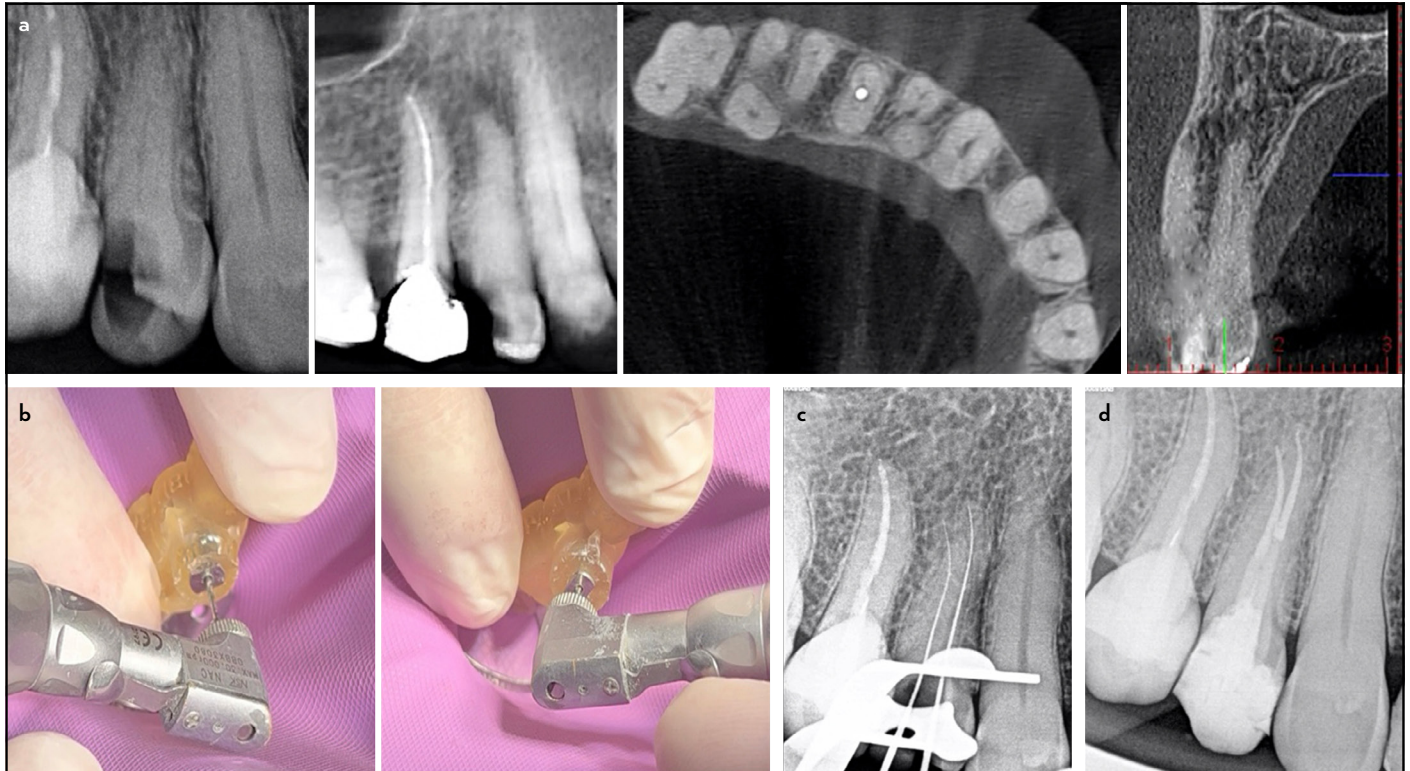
Case 11. (a) Preoperative radiograph and CBCT scan. (b) Two separate guides were used for the buccal and palatal roots, respectively. (c) Radiograph confirming root canal access and patency. (d) Postoperative radiograph
